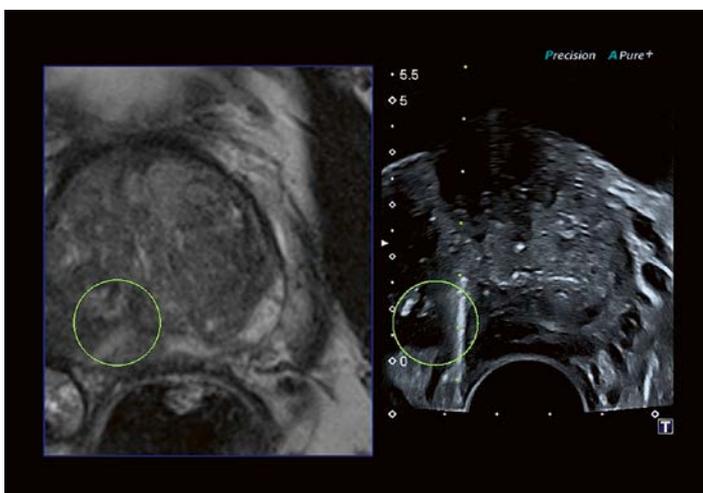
Targeted MRI/US fusion-guided biopsy.
